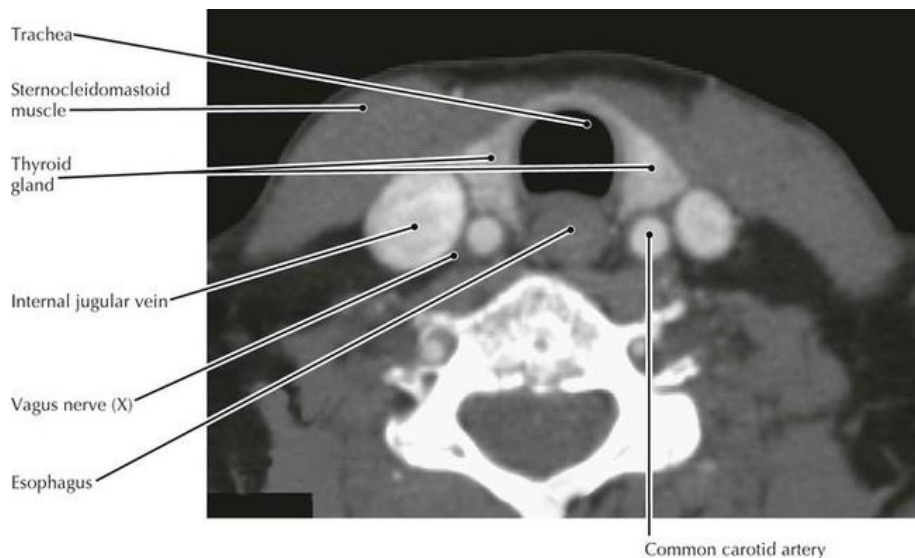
Anterior & posterior relations of thyroid gland by CT scan.
